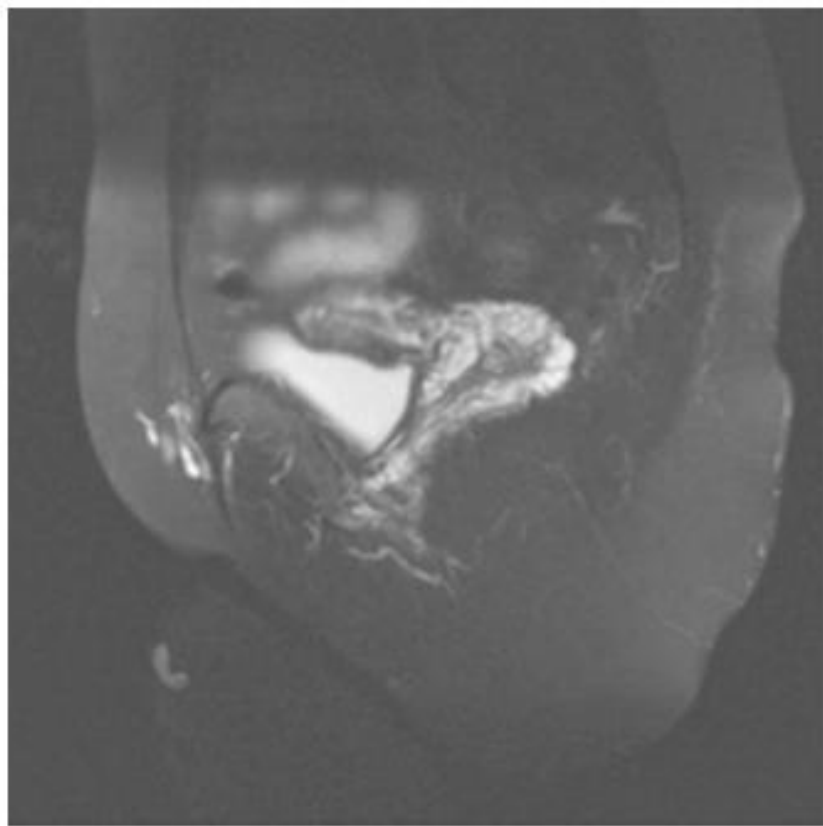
Magnetic resonance imaging scan with contrast enhancement shows extensive varices involving the entire vaginal wall, contiguous with the prominent parametrial veins. Varicosities are also seen in the anterior abdominal wall and in the anterior thigh.
